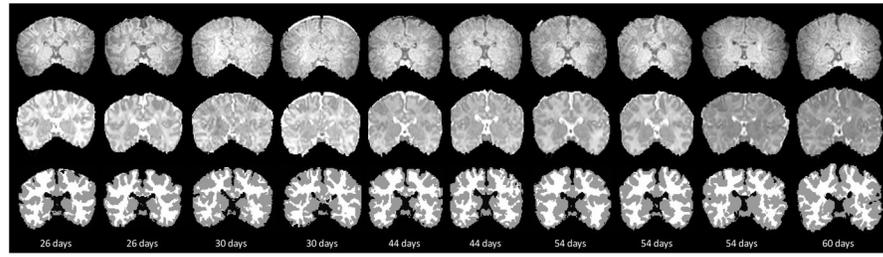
MR images of 10 neonates. The top and bottom panels contain 5 subjects each. In each panel, from top to bottom, are the T1 images, the T2 images, and the segmented images. The ages, in days, are stated at the bottom of each panel.
